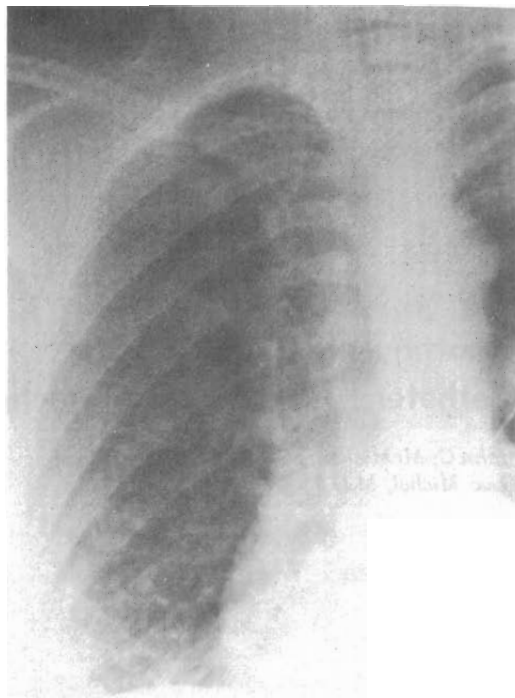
Chest x-ray film showing complete knotting of central venous catheter lying in superior vena cava.
